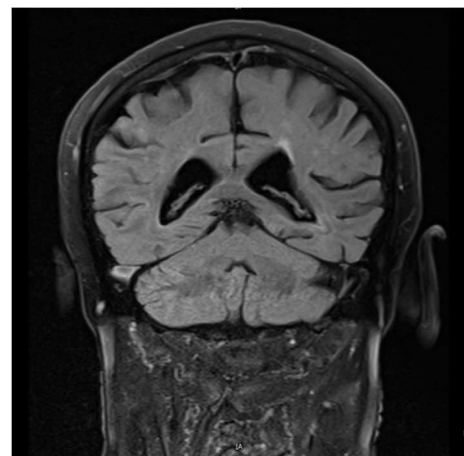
MRI Head Pre-Treatment*
